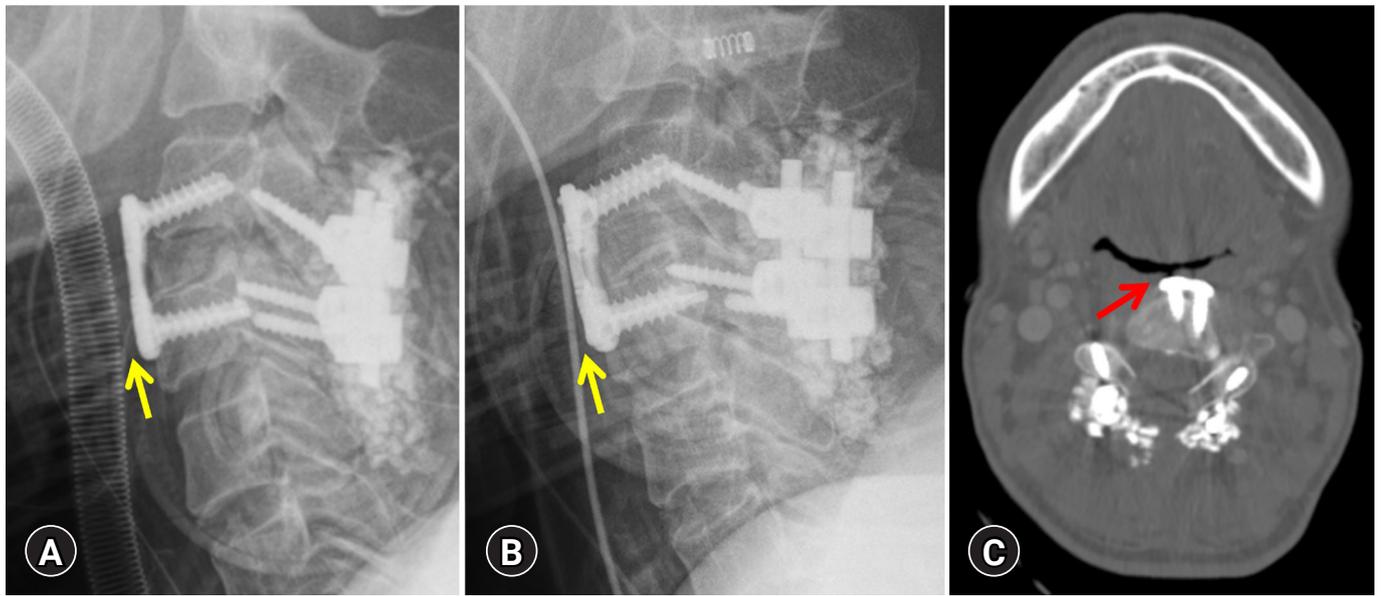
Cervical spine lateral X-ray on (A) postoperative day (POD) 1 after anterior cervical discectomy and fusion surgery and (B) POD 7. The prevertebral soft tissue appears thinned in front of the surgical site (yellow arrows). (C) Horizontal view of computed tomography neck on POD 22. The cervical metal plate used during anterior cervical discectomy and fusion to provide neck stability was found to be exposed to the hypopharynx (red arrow).
